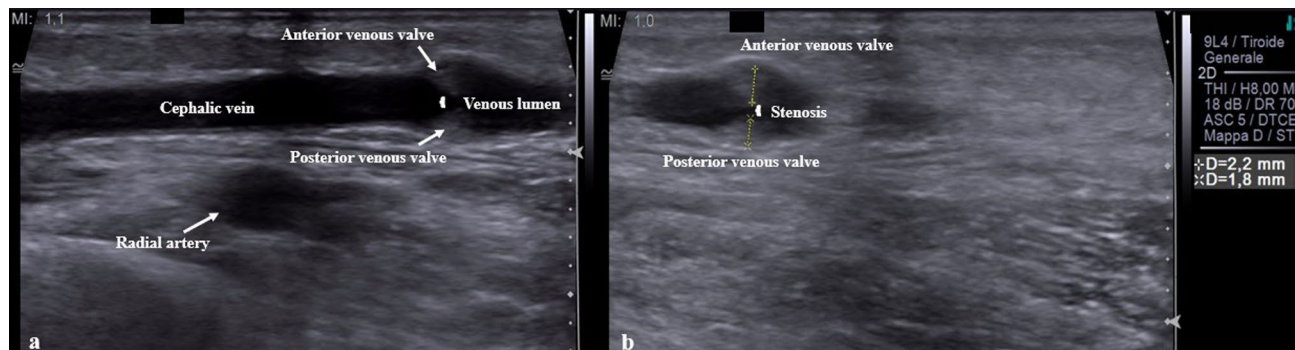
B-mode ultrasound of the outflow (cephalic vein of the forearm). a) The valve leaflets (white arrows) appear finely hyperechoic (calcified) and demonstrate reduced mobility on dynamic ultrasound; b) Increased hyperechogenicity of the valve leaflets with poor mobility on dynamic ultrasound. In both cases, a significant stenosis is observed
